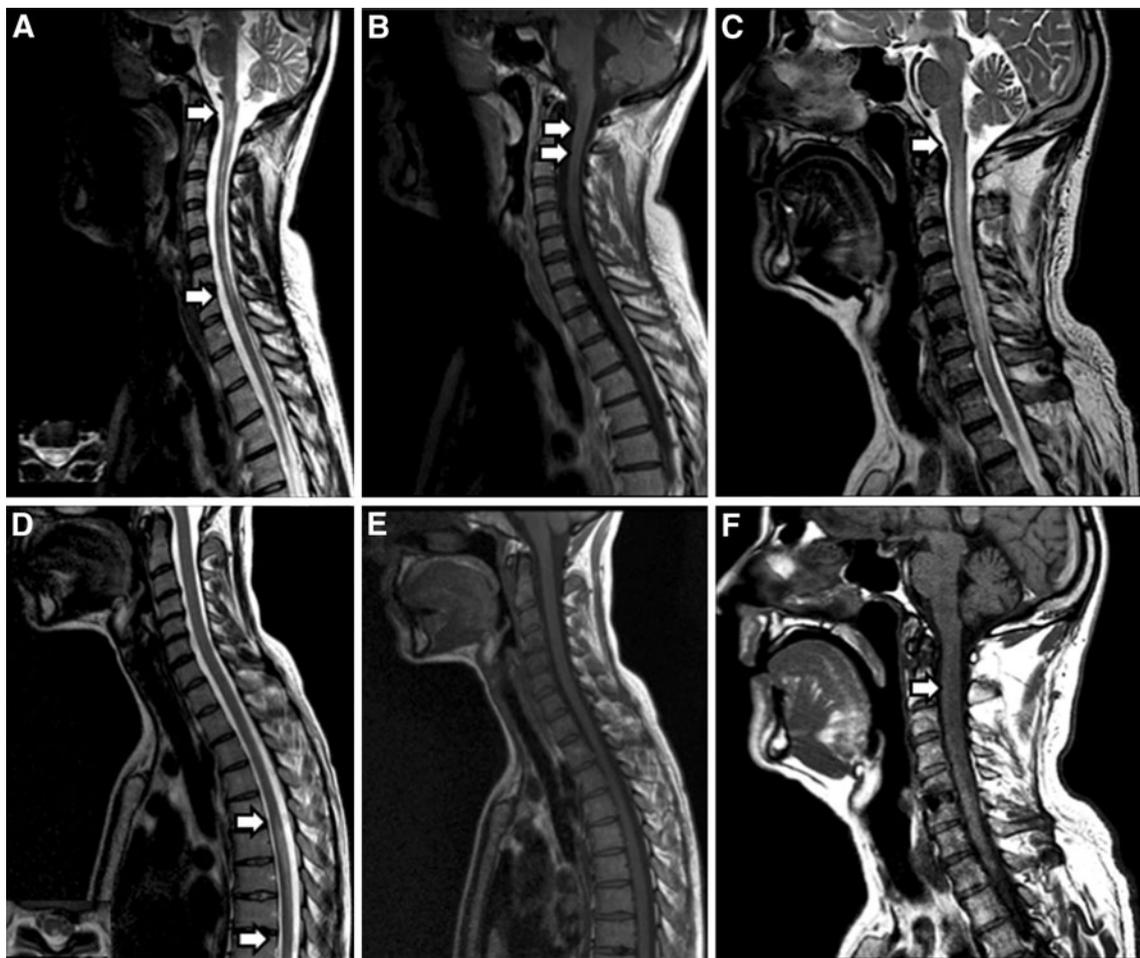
Representative spinal cord MRI images of two different AQP4-IgG+ (A, B, C, F) and one AQP4-IgG− (D, E) LETM patients. Sagittal T2-weighted spinal cord MRI images of AQP4-IgG+ patients show longitudinally extensive inflammatory lesions involving the cervical cord and extending into the medulla oblongata (A, C). Axial T2 weighted images (insert in A and D) show the preferential
